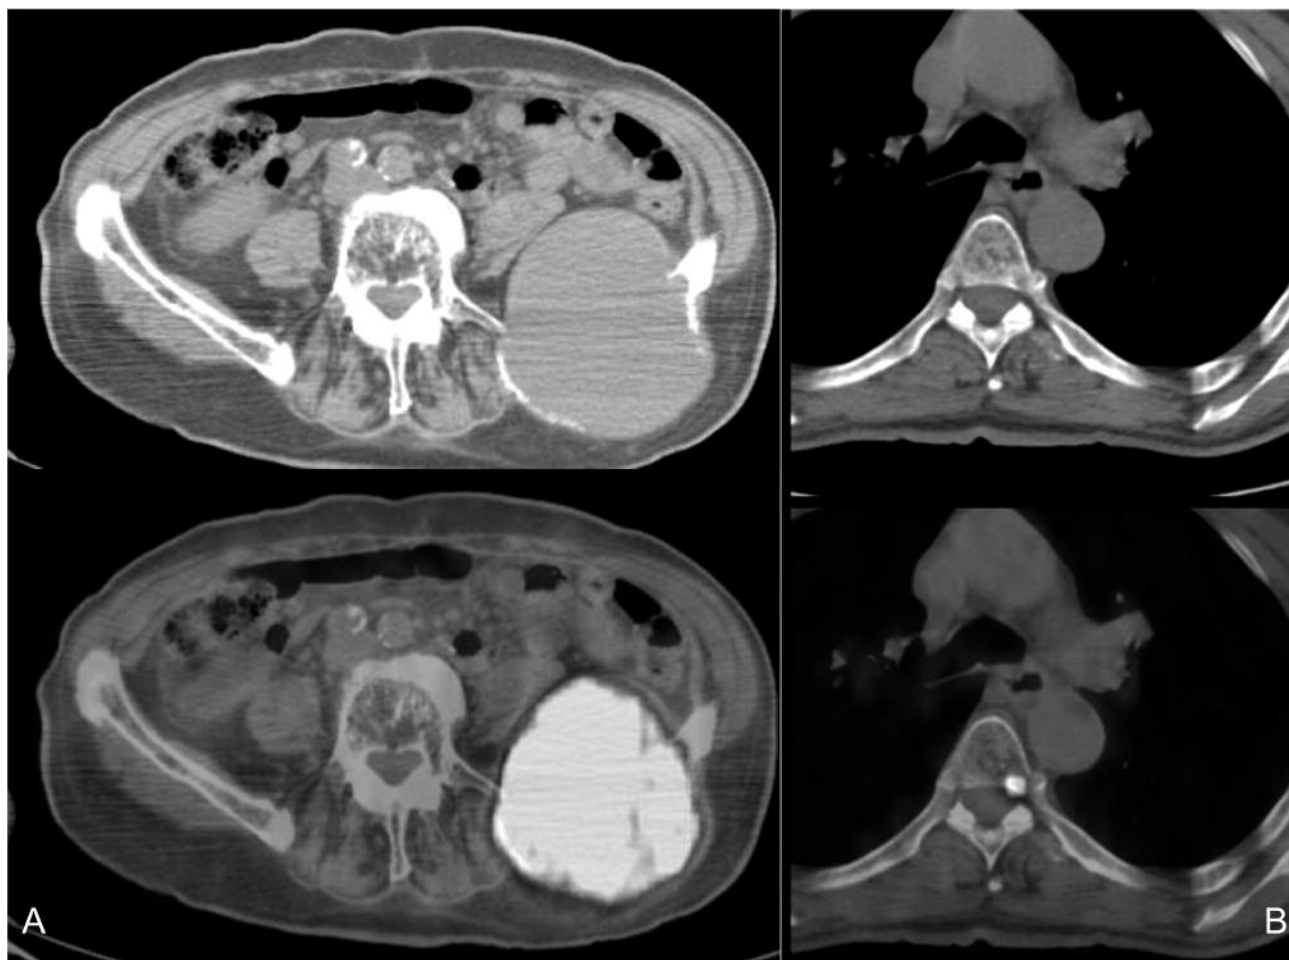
^{18}F -FDG PET/CT of patient no. 8. The image shows increased uptake in the left pelvis lesion (A) and an early tiny hypermetabolic focal lesion in D7, with no morphological changes at CT (B).
